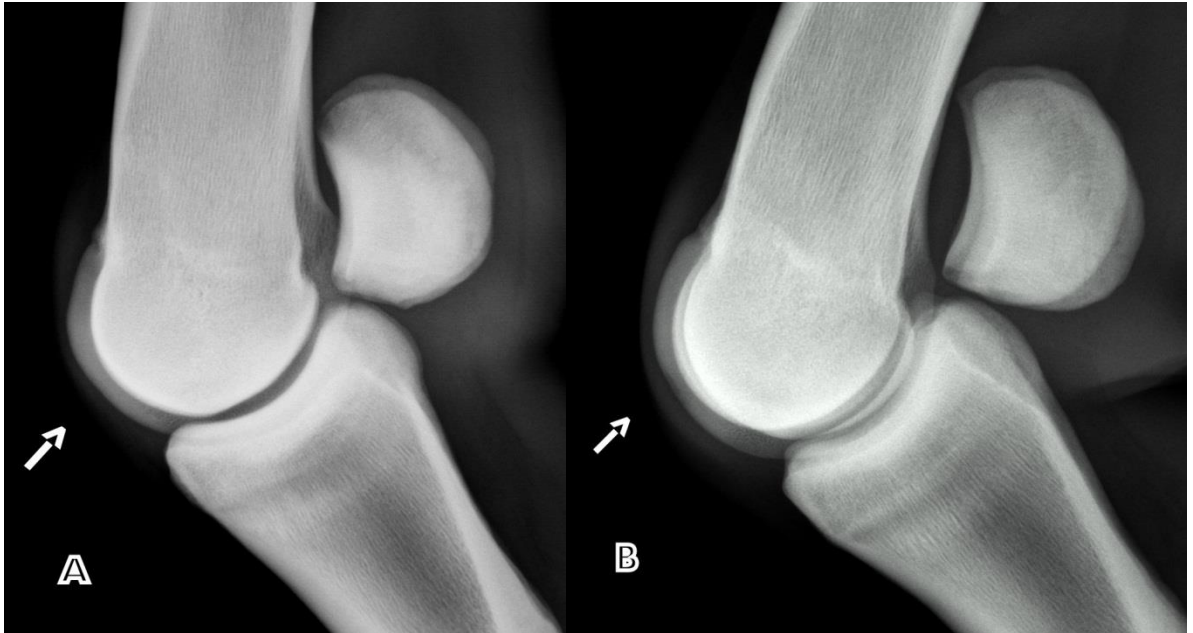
Flexed lateromedial radiographic view of metacarpophalangeal joint showing changes (arrows) seen on the dorsal aspect of the distal third metacarpal bone: (A) a well-defined semicircular notch, (B) lucency and (C) fragment or loose body.
